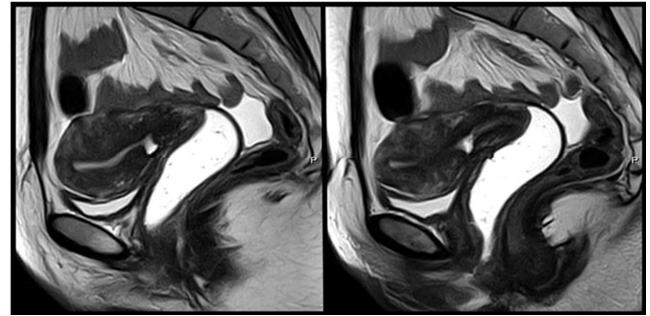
MRI View. A muscular loss and thinning with a hyper-intense cyst-like image within the C-section scar on anterior myometrium, in a sagittal T2-Weighted.
